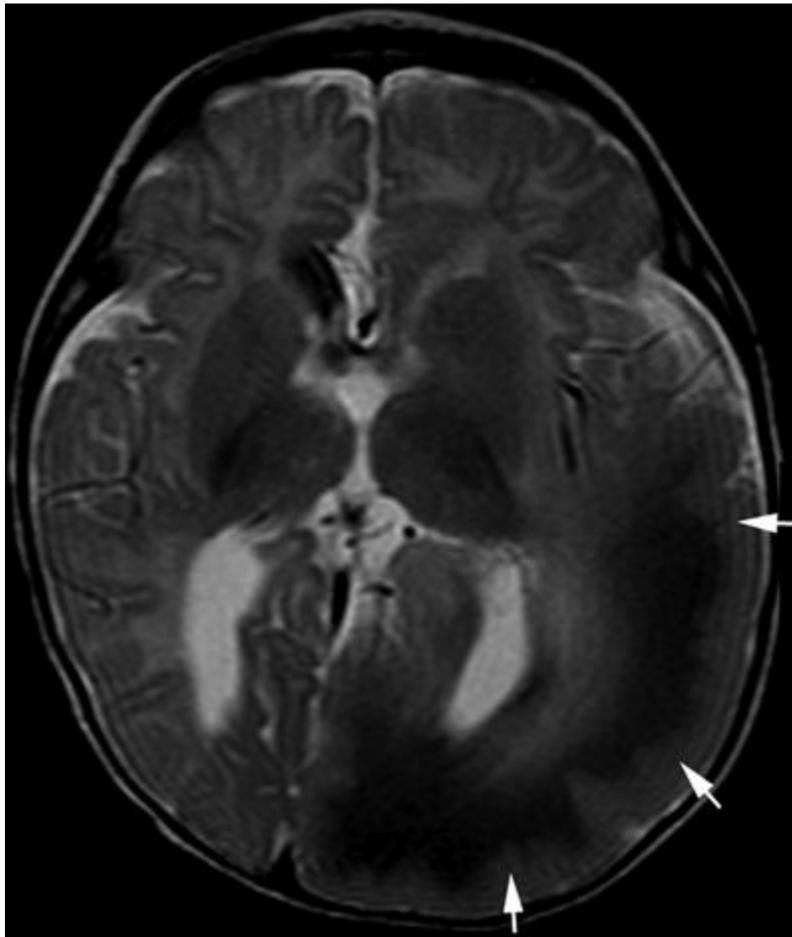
Epidermal nevus syndrome with hemimegalencephaly. Axial T2-weighted image from MRI without gadolinium in a 6-month-old child with facial linear shows generalized enlargement of the left hemisphere with gyral thickening, decreased cortical signal, and blurring of the gray–white interface (arrows).
